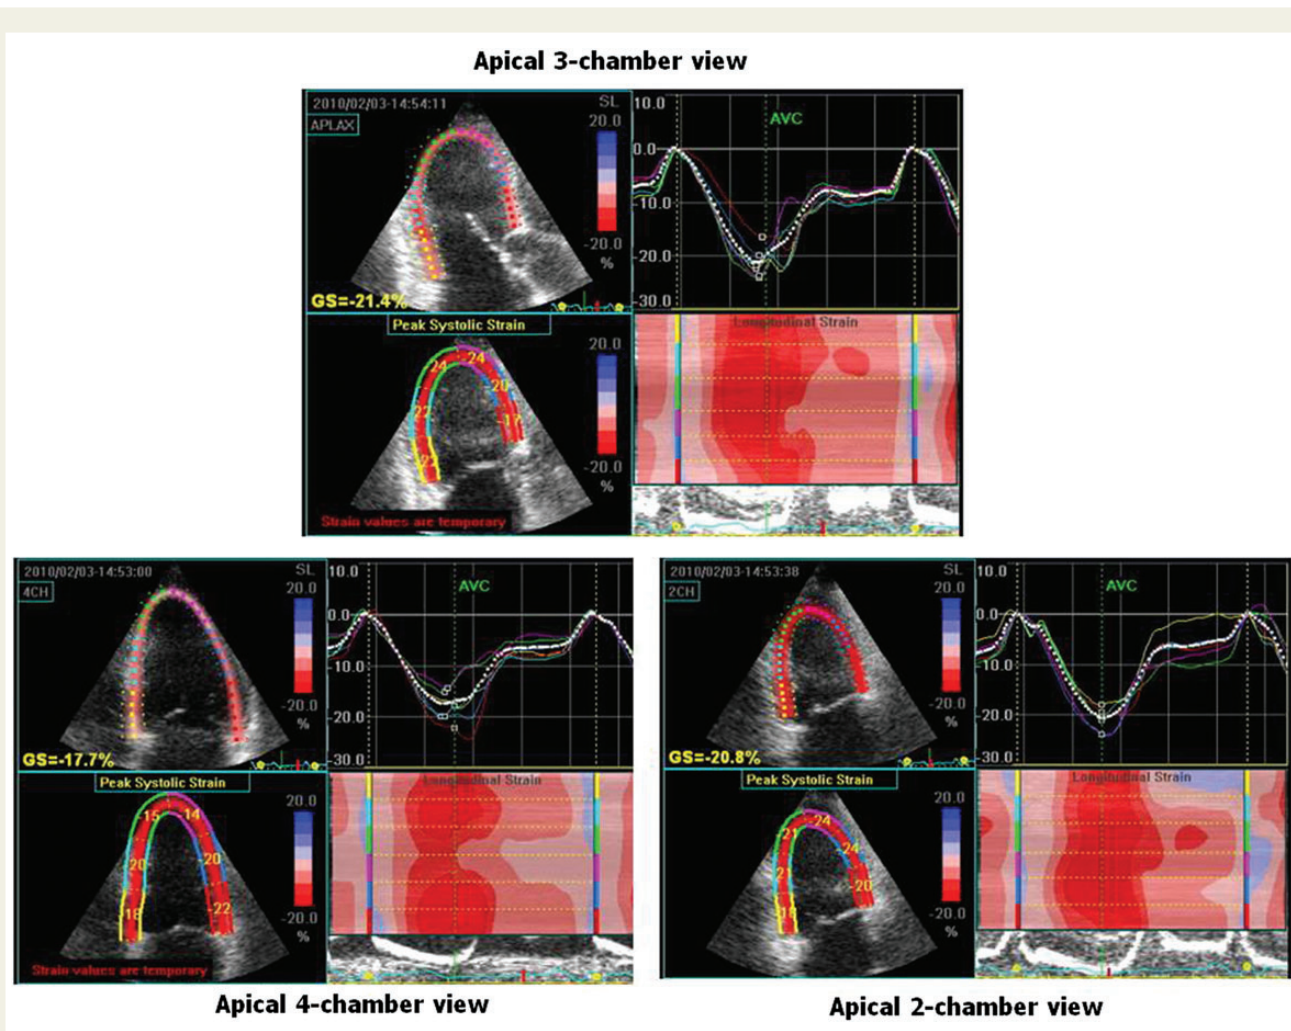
Speckle tracking echocardiography (STE)-derived left ventricular (LV) longitudinal strain during cardiac cycle in the three apical views. In the left section of each view colour representation of STE on 2-D imaging (upper) and quantitation of peak regional strain values (normally negative) referring to six myocardial regions. In the right upper section of each view regional colour systolic curves of systolic strain while dotted white line corresponds to average strain (GLS). In the right lower section qualitative colour M-mode strain representation referring to the six consecutive myocardial segments: at the bottom LV basal right segments (red colour) of each view, at the central part LV apex, at the top LV basal left segments (yellow colour) of each view; red and pink colours refer to systolic deformation.
